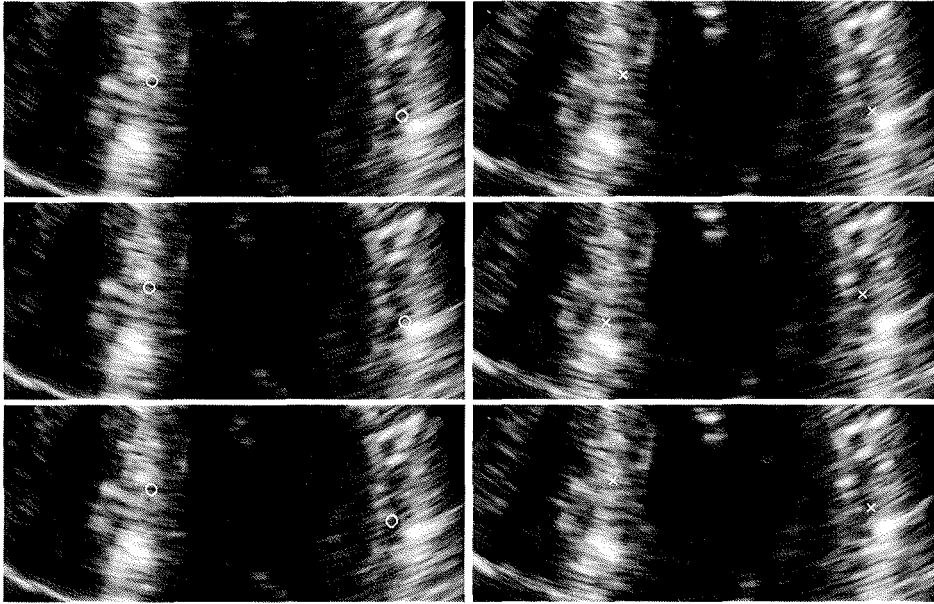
A movie showing the B-mode cine-loop used in figures A.4-A.6. Six displays are shown synchronized: Original data with 40 frames per second in the left column and decimated data with 10 frames per second in the right column. Tracking results are plotted on-top of the ultrasound images for three velocity estimators: Tissue Doppler (top), speckle tracking (middle) and DAST (bottom). *Thesis comment: The movie was part of the published paper and is available at <http://folk.ntnu.no/sveinbr/TviMorphingSamples/AnatomicTracking.mpg>.*
